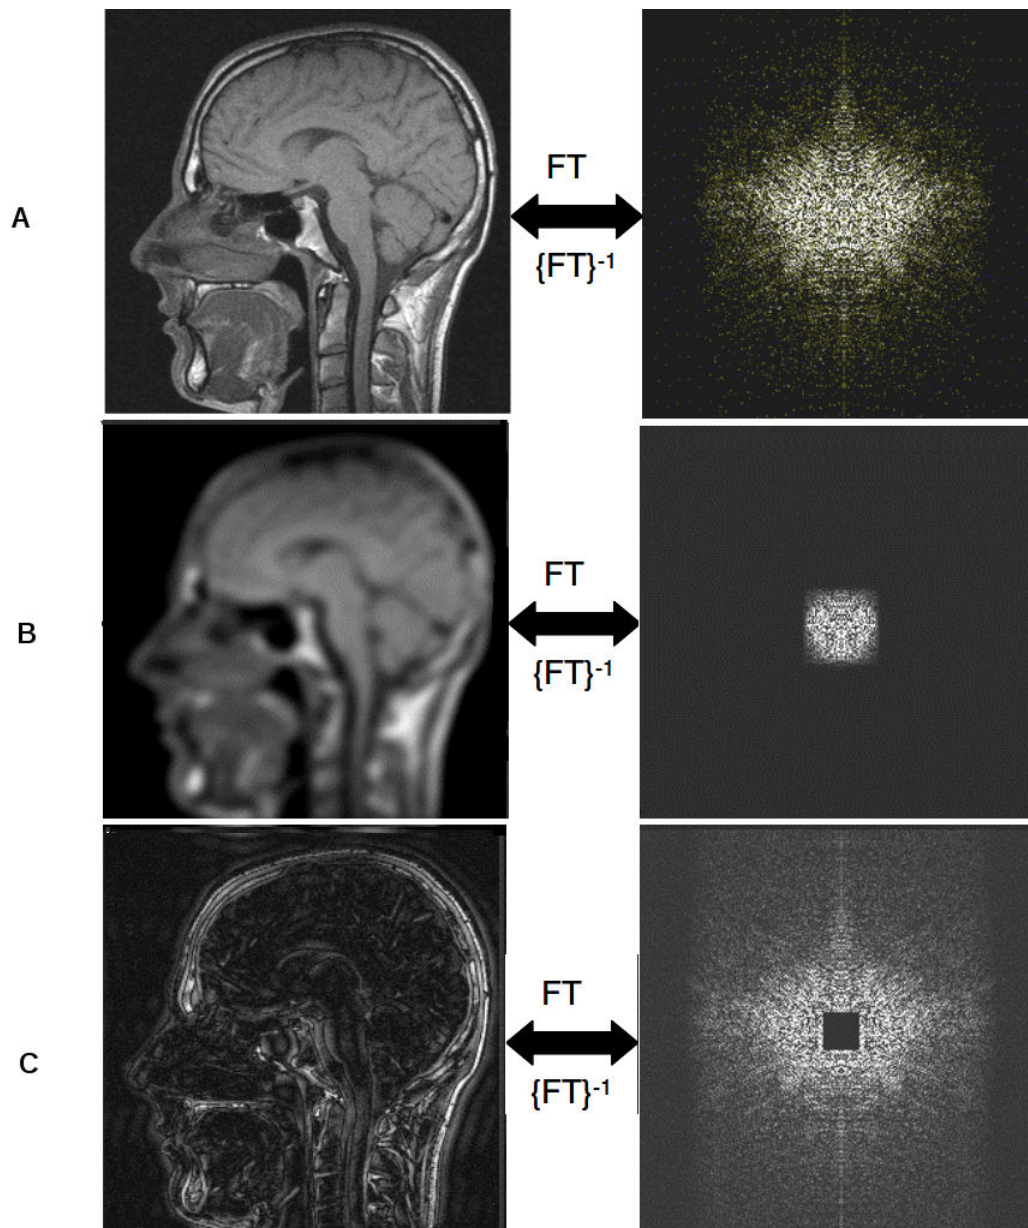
The left column shows the magnetic resonance image and the right column shows the corresponding k -space. The top row (A) shows the full k -space and the corresponding MR image. The middle row (B) shows the image constructed from only the central section of the k -space which contains the image contrast information but the image is blurry as it does not contain any information about the image resolution. The bottom row (C) shows image constructed from only the information in periphery of k -space. The image has no contrast information.
